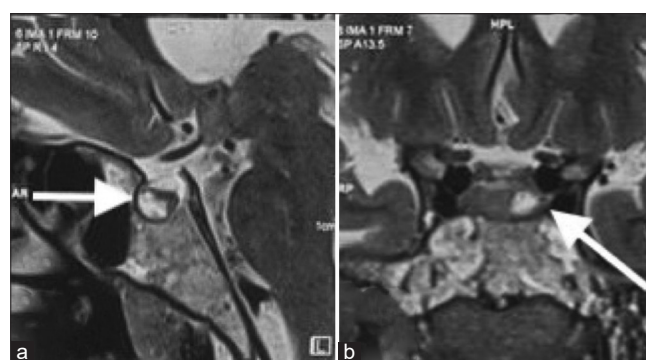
(a) Sagittal magnetic resonance imaging (MRI) brain showing a hypoenhancing lesion (white arrow) in the left half of the pituitary gland, measuring approximately 9 × 8 × 7.2 mm. (b) Coronal MRI brain showing heterogeneously hyperintense lesion in the pituitary gland, on T2 with multiple peripheral T2 hypointense foci, suggestive of microadenoma (white arrow).
